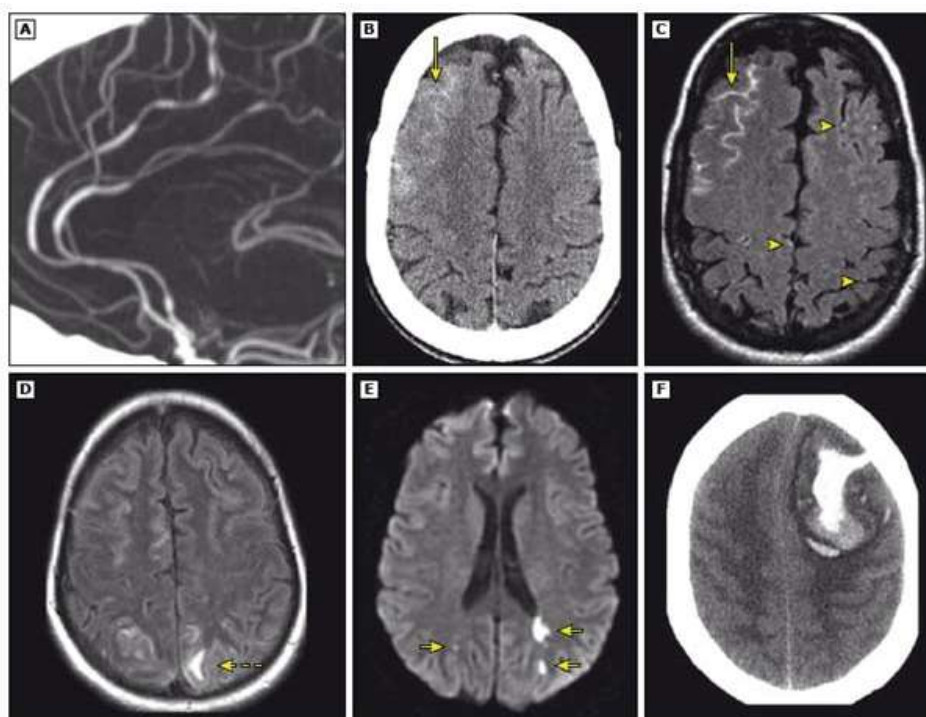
(A) Head CT angiogram: sagittal image showing the classic “sausage on a string” appearance of both anterior cerebral arteries.
